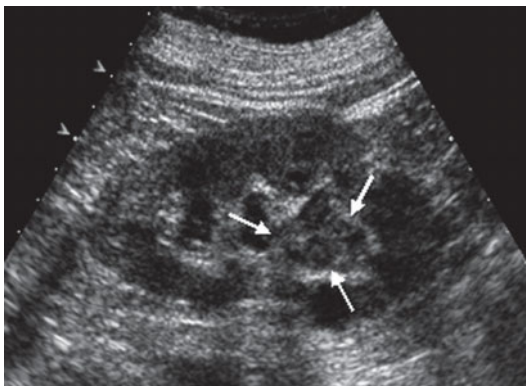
Ultrasonography. Transitional cell carcinoma. Sonogram show an ill-defined solid iso-hyperechoic lesion at the level of the inferior caliceal system (*arrows*)
